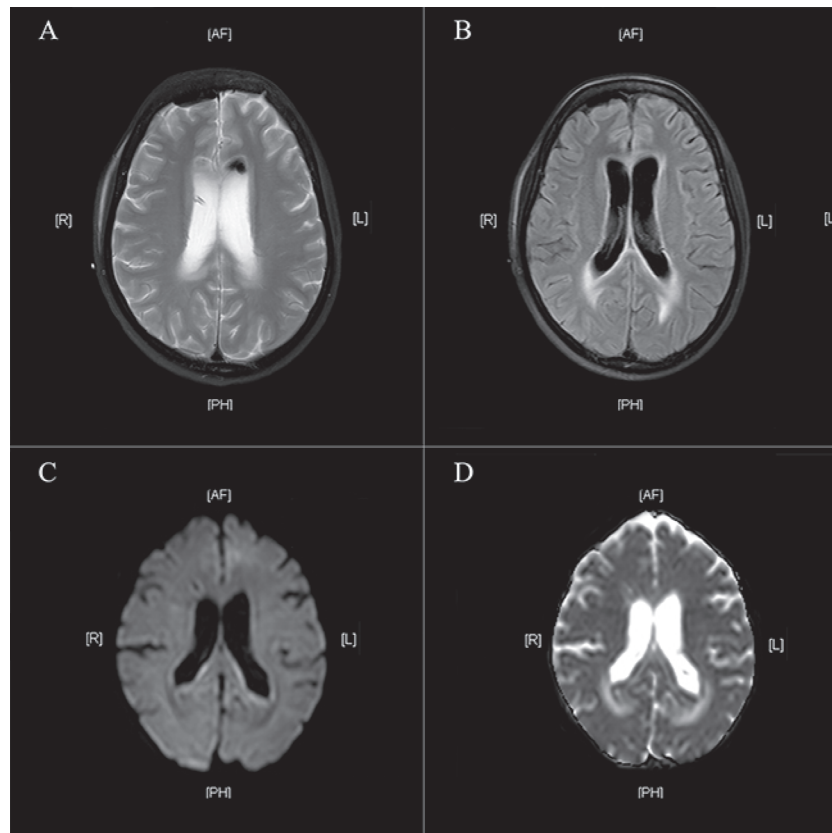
Contrast-enhanced MRI of the brain showing numerous periventricular high T2-signal regions with restriction on diffusion-weighted imaging (DWI). (A) T2-weighted image, (B) T2 FLAIR (fluid-attenuated inversion recovery) image, (C) DWI and (D) apparent diffusion coefficient image.
